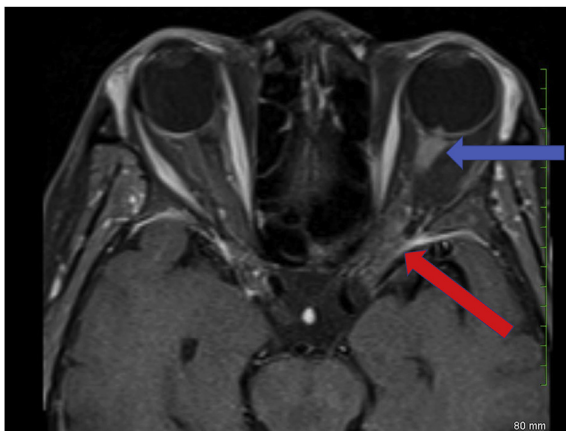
Post-contrast MRI of the brain and orbits taken within a week of initial presentation demonstrating subarachnoid spread of tumor in the bifrontal regions and left optic sheath (red arrow) as well as proximal enhancement of the left optic nerve and optic disc (blue arrow).
